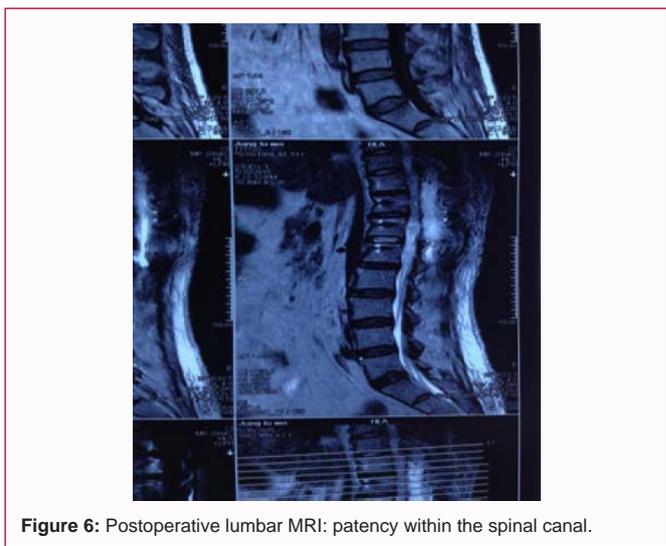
Postoperative lumbar MRI: patency within the spinal canal.
